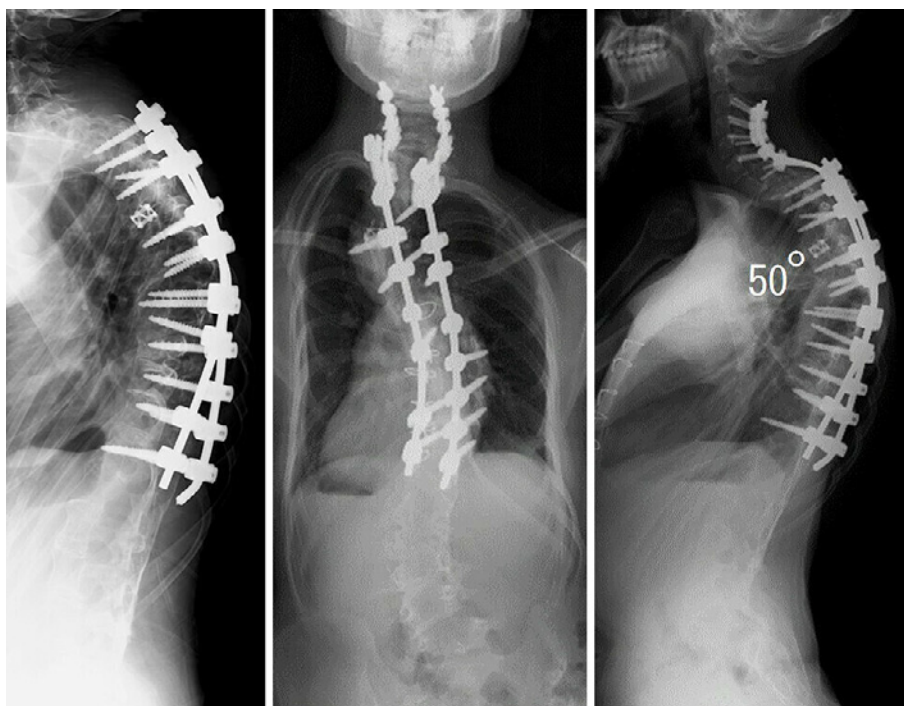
Radiographs after final correction and fusion surgery with T4 VCR.
